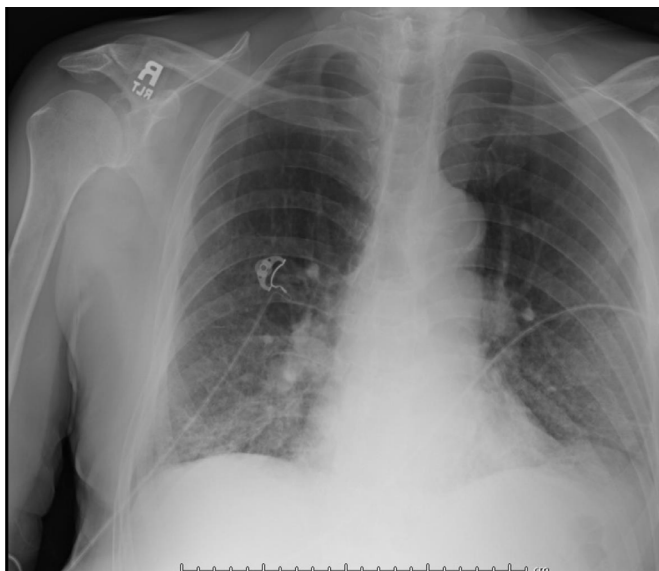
Chest Radiograph (AP view): Upper lung emphysematous changes. Nonspecific bibasal airspace disease which could represent atypical infection or pulmonary edema superimposed on chronic inflammatory changes. Stable mediastinal contour and heart size. No large effusion or pneumothorax.
